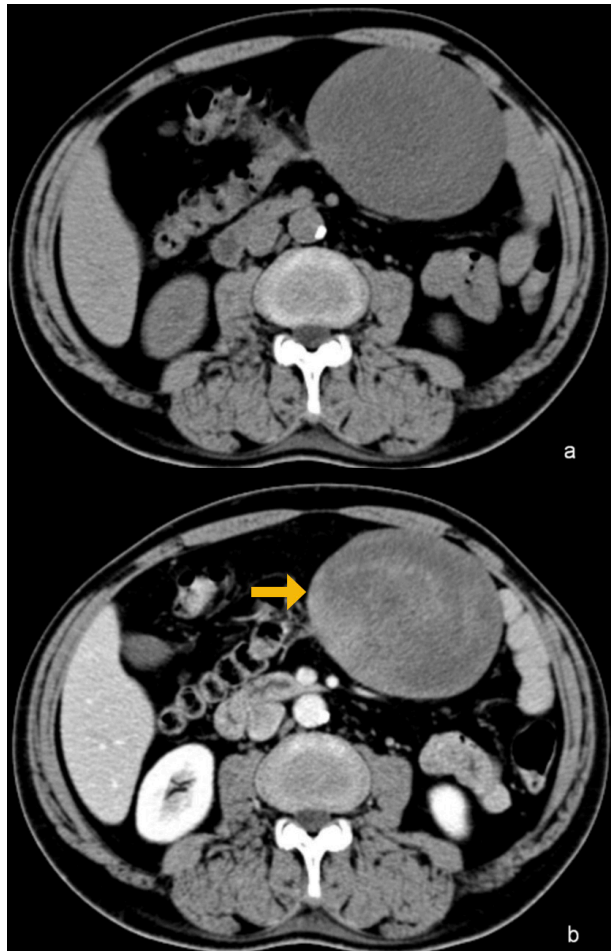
Intraabdominal fibromatosis in a 39-year-old female. Axial non-enhanced (a) and enhanced (b) CT images showing a well defined, heterogeneously enhancing peritoneal mass. Note the well-defined borders of the lesion (arrow).
